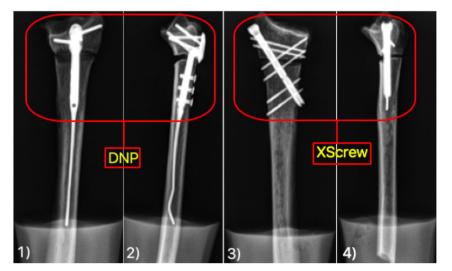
Postoperative radiographs with implant fixation prior to biomechanical testing. 1-2) After fixation with a DNP. 3-4) After fixation with an XSCREW, adapted from [83].
